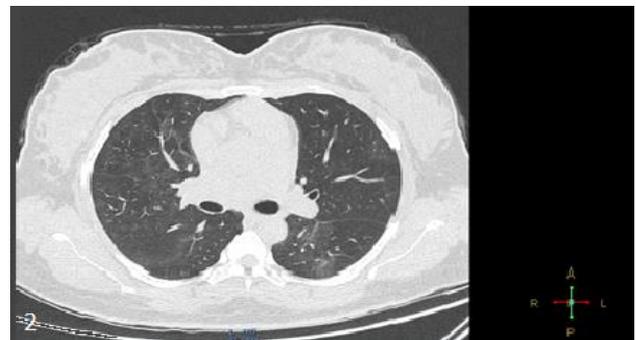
HRCT image of peripheral ground glass opacities (CT scoring 25-50%).
